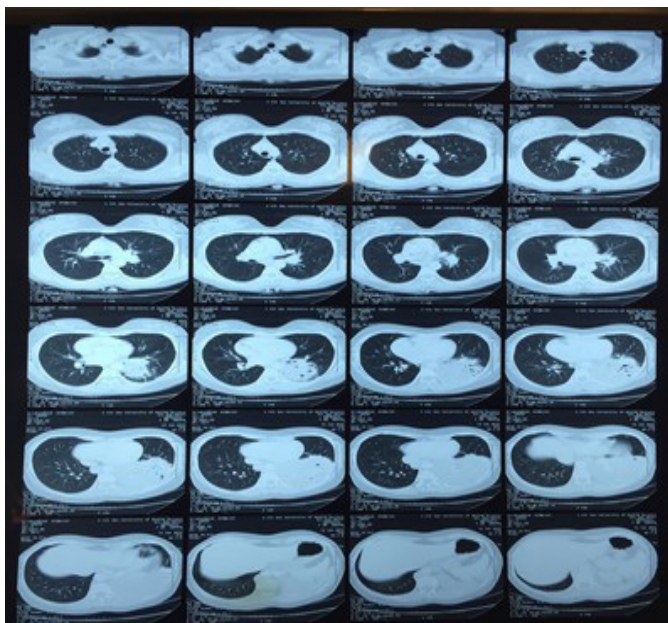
CT-scan chest showing non homogenous opacity in left lobe of lung.
